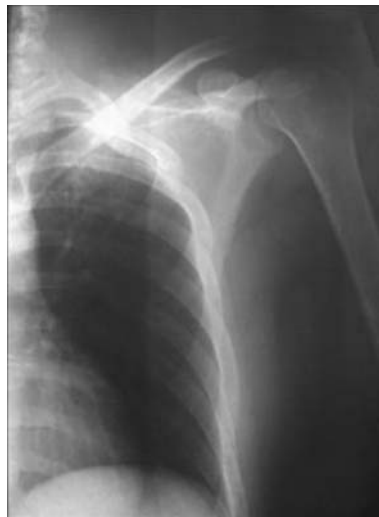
Thoracic X-ray is normal.
